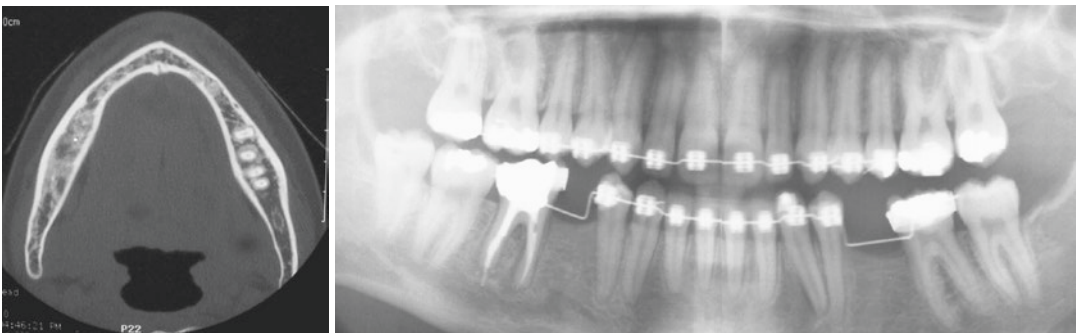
CT and OPG as ante-mortem material of a missing subject
